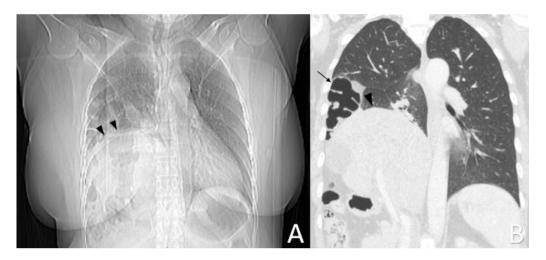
(A) The chest X-ray demonstrates a significant elevation of diaphragmatic dome (black arrowhead). B: The upper border of the herniated liver is clearly above the normal level on the chest CT with coronal view (black arrowhead). A part of the large bowel is also visible (black arrow).
